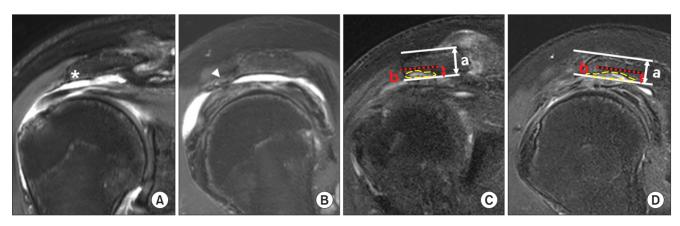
Mild acromial cupping of the acromial undersurface. (A) Preoperative T2-weighted oblique coronal magnetic resonance (MR) image showing a mild heel type spur (asterisk). (B) Preoperative T2-weighted oblique sagittal MR image showing an anterior bird beak spur (arrowhead). (C) Postoperative T2-weighted oblique coronal MR image showing mild acromial cupping (yellow dotted line). The depth of acromial cupping (b) versus acromial height (a) was < 1/3. (D) Postoperative T2-weighted oblique sagittal MR image showing mild acromial cupping (yellow dotted line).
